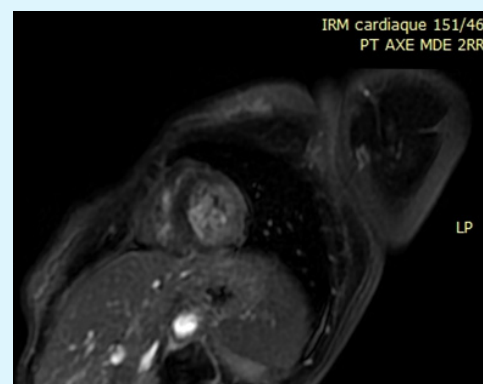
Cardiac MRI – Late Gadolinium Enhancement (LGE)
